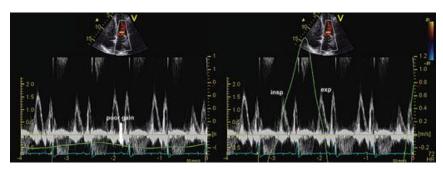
CP: apical four-chamber view with PW Doppler recording of the mitral inflow in a patient with CP. (*Left*) The respirometer waveform is indistinguishable because of poor gain. After adjustment (*right*) the respiratory waves are now able to clearly distinguish inspiration and expiration.
